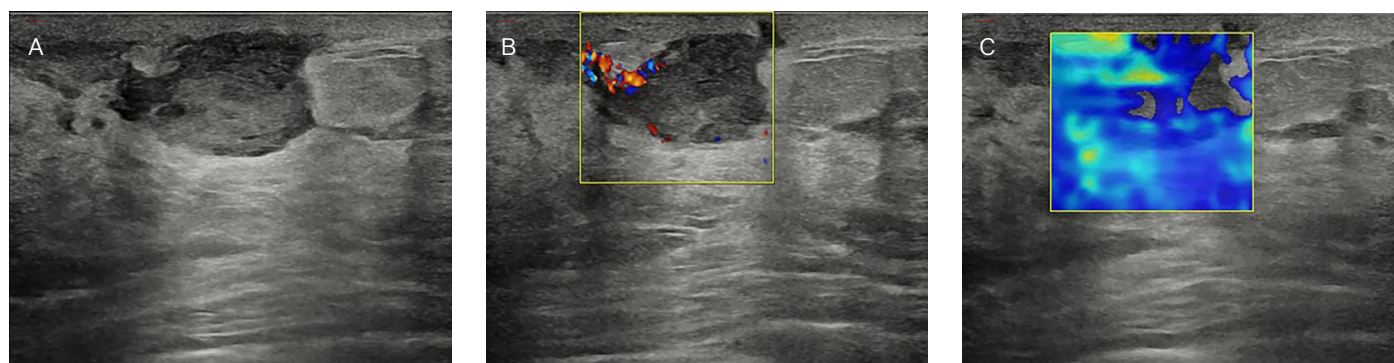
28-year-old woman who presented with a tender, rapidly growing left-breast mass. Antibiotic treatment trials were unsuccessful. Abscess aspirations yielded sterile cultures and no malignancy. Pathology result was reported as IGM. (A) and (B) Ultrasound images obtained at the 2-o'clock to 6-o'clock position in the left breast for shows a complex mass with solid and cystic components and internal vascularity. The mass was believed to represent surrounding inflammation and/or granulation tissue associated with abscess formation. (C) Elastographic examinations show that the elasticity value of the lesion is in the benign category according to the Tsukuba scoring system.
